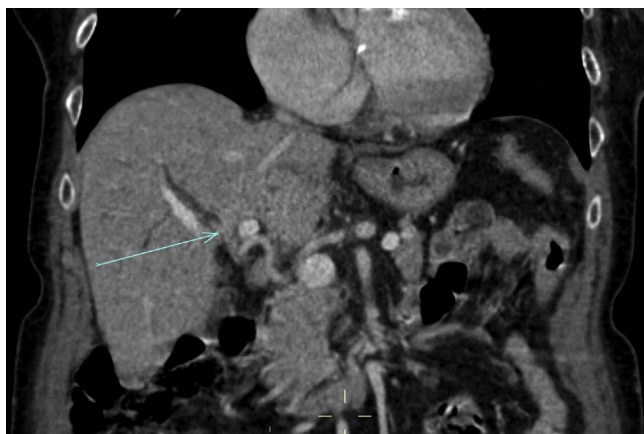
CT scan of Klatskin cholangiocarcinoma.
